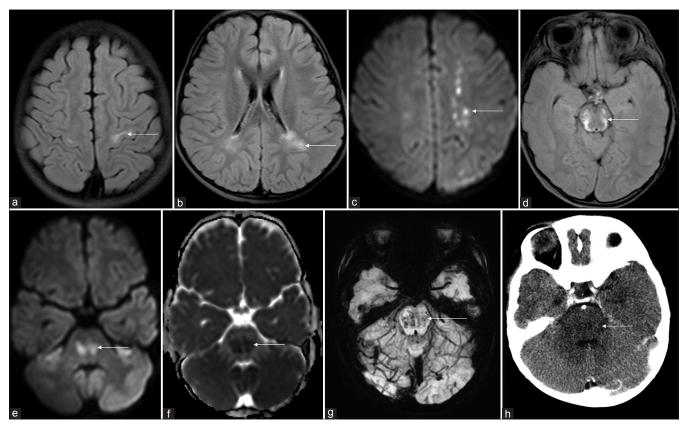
Magnetic resonance imaging fluid-attenuated inversion recovery axial images (a and b) bilateral white matter hyperintensities in the precentral gyrus and posterior periventricular region. Diffusion-weighted image (c) multiple foci of restriction in the left centrum semiovale. Fluid-attenuated inversion recovery axial image (d) symmetric midbrain hyperintensity. Diffusion-weighted image and apparent diffusion coefficient image at pontine level (e and f) restricted diffusion. Susceptibility-weighted image (g) hypointense foci in pons suggestive of bleed. Computerized tomography brain (h) hypodensity and swelling of the pons
